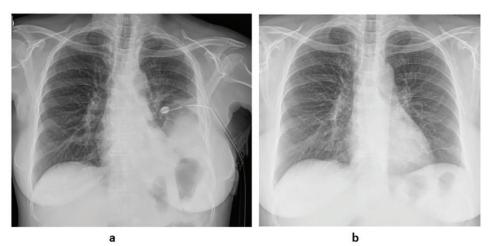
A) Chest X-ray showing left sided pleural effusion with intercostal draining tube in the left lower zone. B) Chest X-ray showing resolution of pleural effusion after first cycle of chemotherapy.
